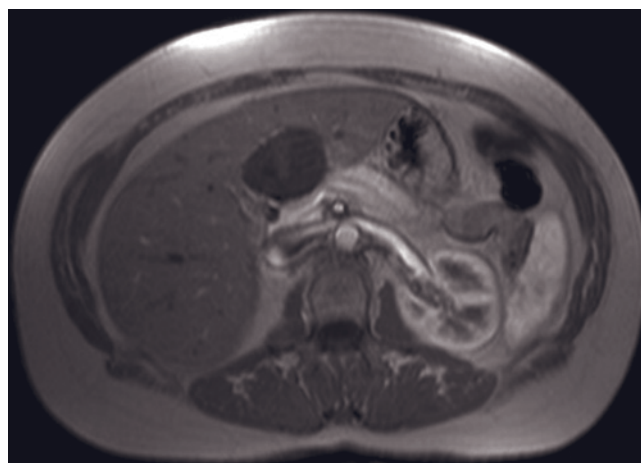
(Continued) Transverse T2-weighted SS-ETSE (g), SGE (h), and immediate (i), 45-s (j), and 5-min (k) postgadolinium SGE images in a second patient. There are two lobular lesions that appear high in signal intensity on T2-weighted image (arrows, g) and low in signal intensity on T1-weighted (h) images. The first lesion is situated in the left lobe, demonstrates peripheral nodular enhancement after administration of gadolinium, and gradually fills in completely on delayed images (k), consistent with a Type 2 hemangioma. The other lesion is situated in the right hepatic lobe and shows peripheral nodular enhancement that progresses centripetally but with persistence of a central scar on the delayed image consistent with a Type 3 hemangioma. Note also multiple tiny lesions throughout the hepatic parenchyma consistent with biliary hamartomas.
